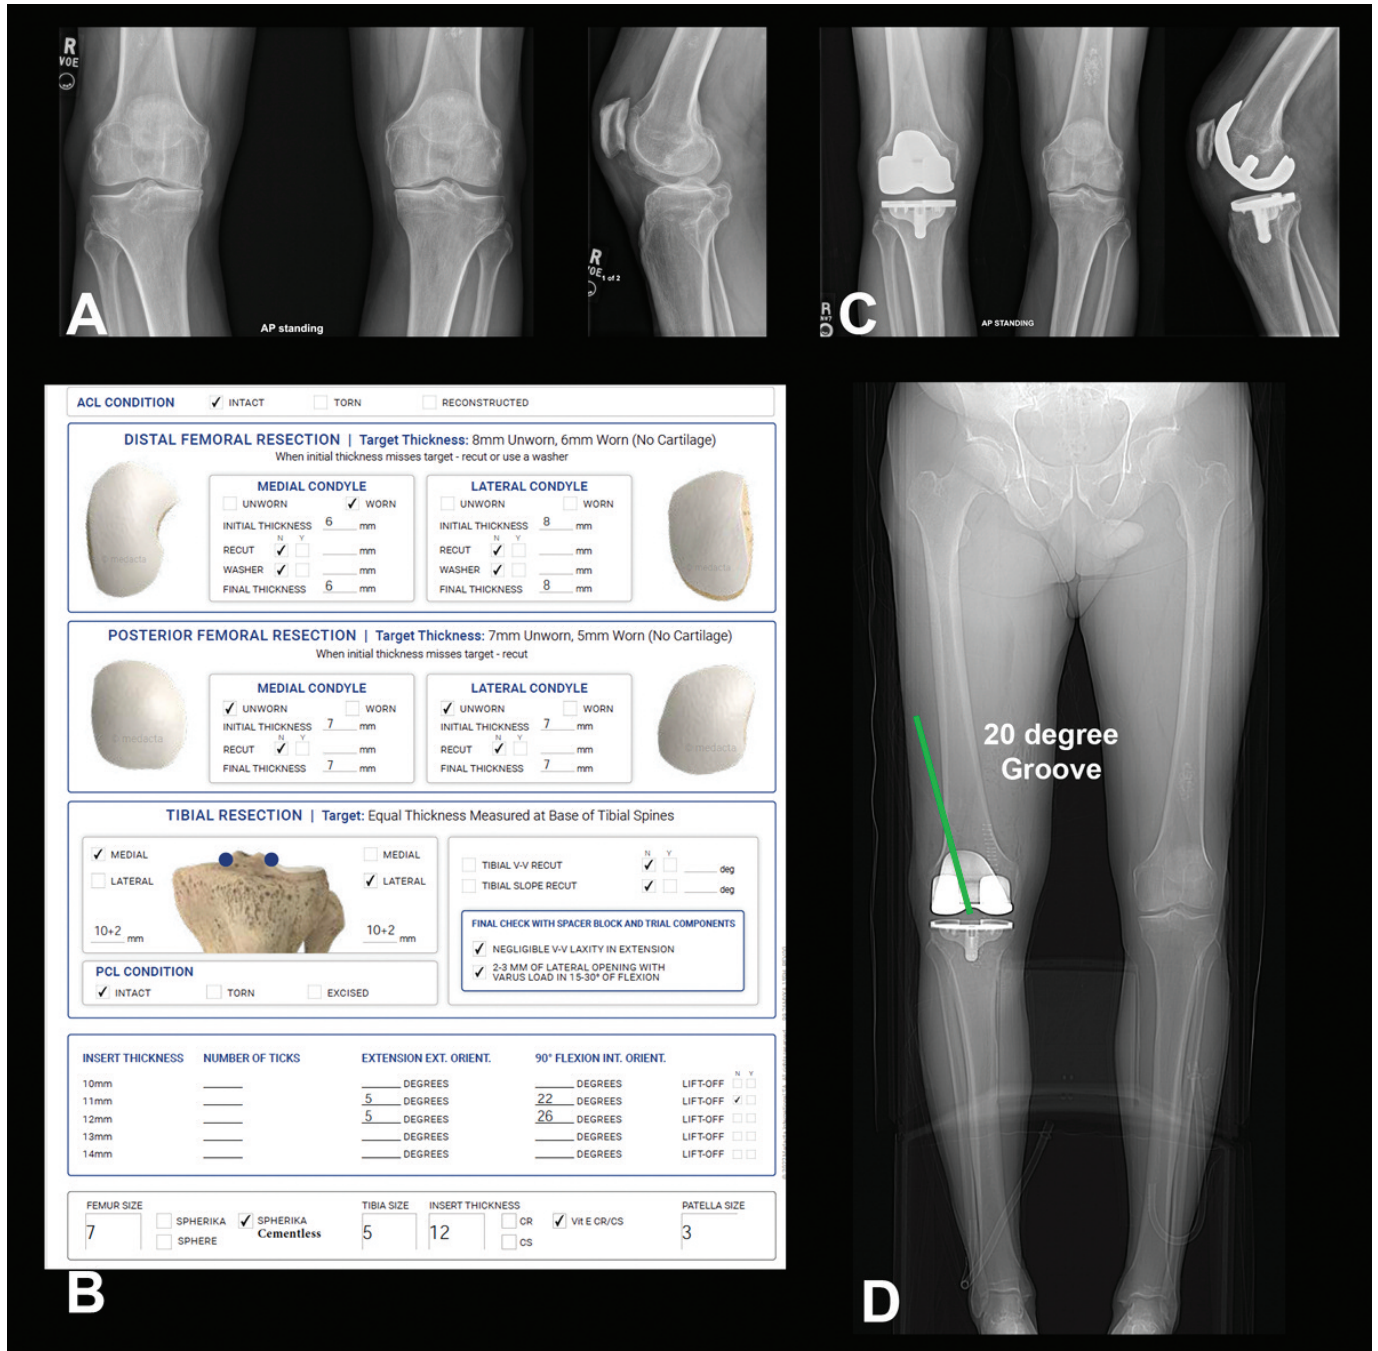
Preoperative weight-bearing radiographs (A), an intraoperative verification sheet documenting the caliper-measured thickness of the femoral and tibia resection thickness (B), postoperative weight-bearing radiographs six weeks postoperatively (C), and a non-weight-bearing long-leg computed tomography (CT) scanogram (D) of a typical patient who underwent a KA TKA with PCL retention.
